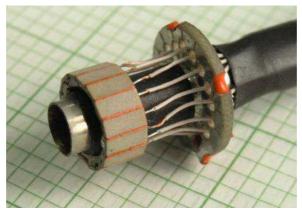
Ultrasonic 16 element array prepared for experiments in water
